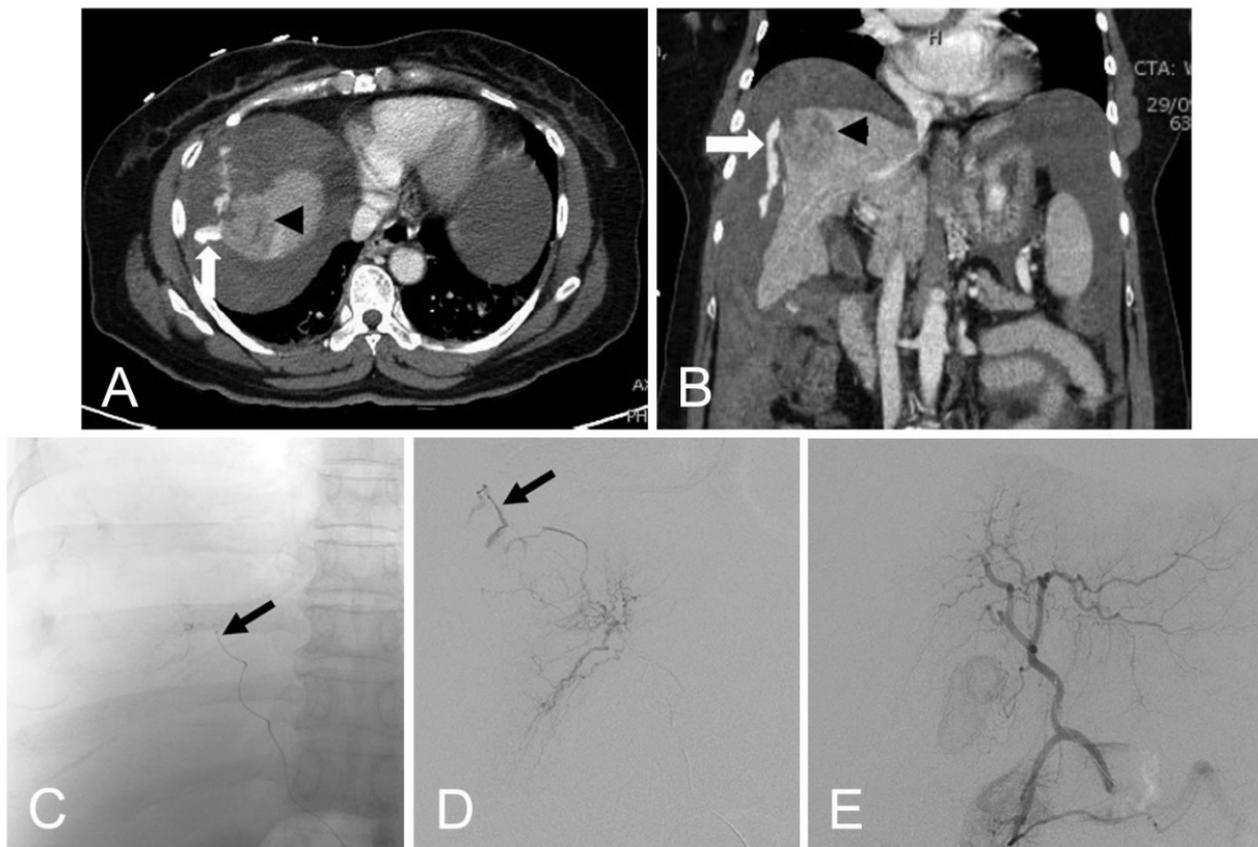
A 55-year-old female with hepatitis B cirrhosis and HCC presented with syncope and hypotension. A. Axial and B. Coronal contrast enhanced portal phase CT scan shows a well encapsulated mass with portal washout at segment 8 of the right hepatic lobe (arrowheads) with ascites and active contrast extravasation (white arrows). C. Scout film angiogram showed a microcatheter placing at superior right hepatic lobe (arrow) D. Selective right hepatic angiography shows a hypervascular lesion with active contrast extravasation from the A8 branch of the right hepatic artery (arrow). E. Post-embolization angiography shows disappearance of the contrast extravasation.
